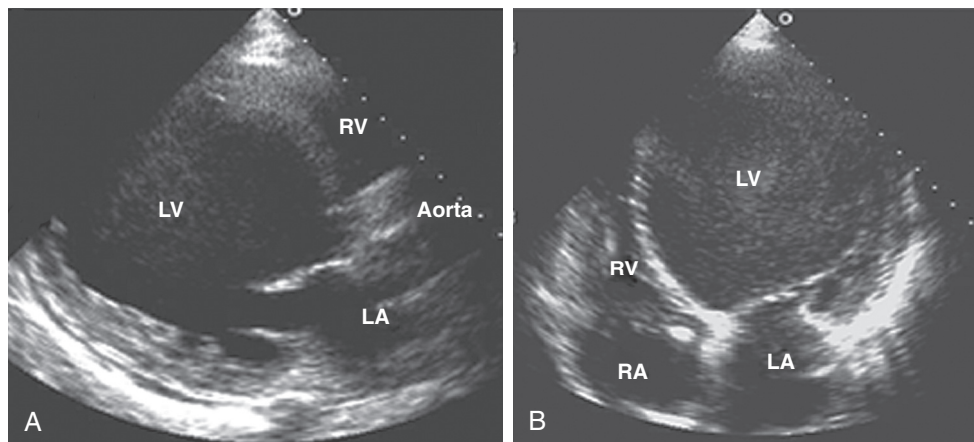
■ Dilated cardiomyopathy. Transthoracic examination of a severely dilated left ventricle (LV) in the parasternal long-axis (A) and apical four-chamber (B) views. The 65-year-old patient presented with flash pulmonary edema and later was found to have severe diffuse coronary artery disease. LA, left atrium; RA, right atrium; RV, right ventricle.
